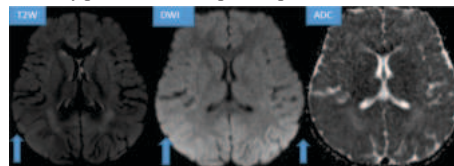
Periventricular hyperintensities on T2W & FLAIR showing no diffusion restriction in a case hypoxic ischaemic encephalopathy in a term infant.
